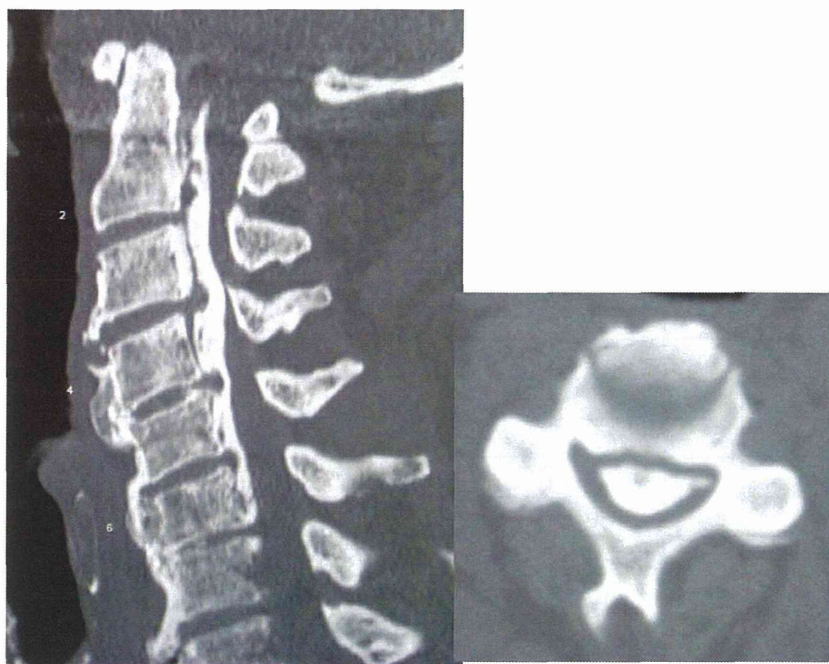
Computed tomographic scan of the cervical spine showing ossification of the posterior longitudinal ligament in an 87-year-old Chinese America male. The continuous type of ossification of the posterior longitudinal ligament occupies 88% of the spinal canal.
